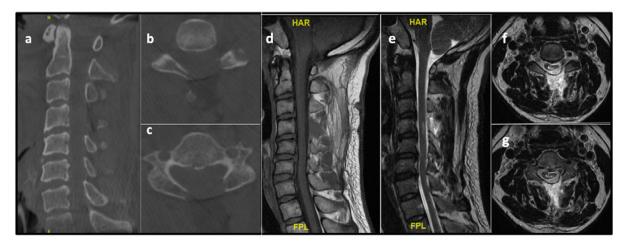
CT (A) Sagittal view showing decompression and preserved tip of spinous process (B) and (C) Axial view showing removed osteochondroma and preserved tip of spinous process. MRI (D, E, F, G) showing adequate decompression of spinal cord with residual myelomalacia along with preserved posterior ligamentous complex.
